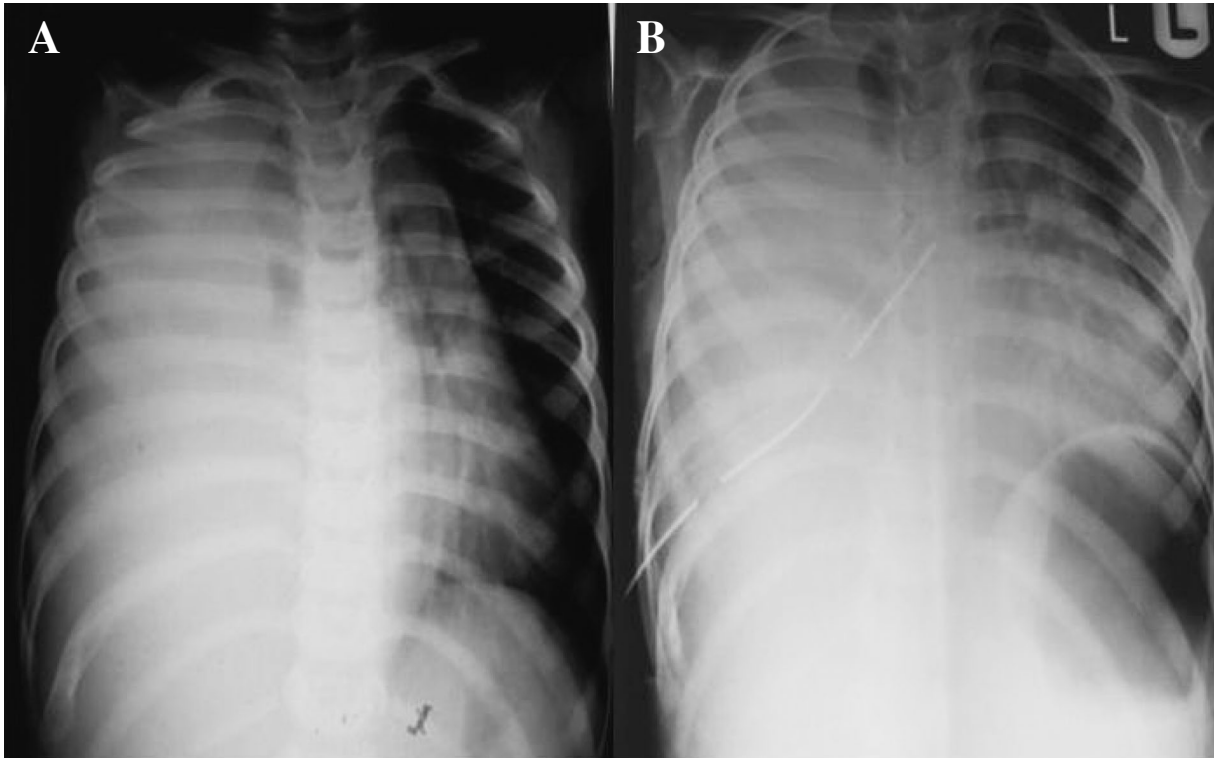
Pre and post intercostal drainage chest X-ray showing persistence of right sided chest homogenic appearance due to tumor, which was previously thought to be due to effusion.
